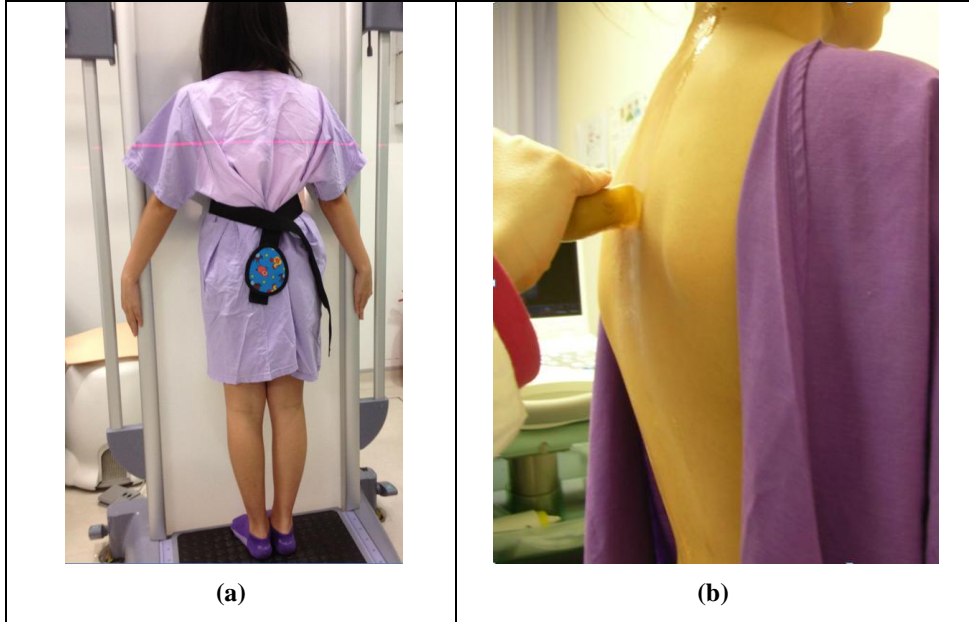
(a) Position for Taking Radiography
